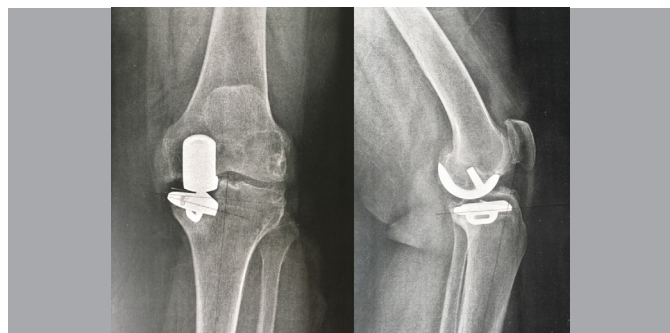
4th year postoperatively, anteroposterior/lateral X-ray view of unicompartmental knee arthroplasty with tibial plateau angle 8° valgus.
